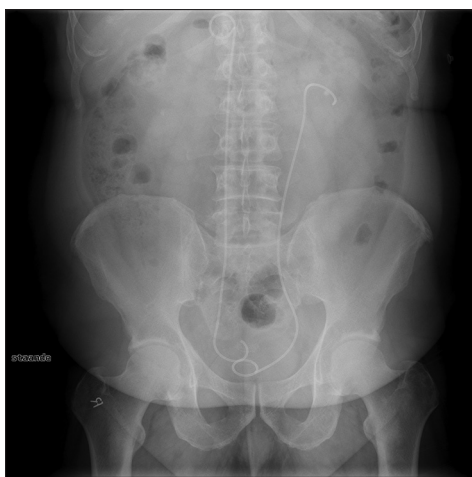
Peroperative kidneys, ureters, and bladder X-ray after the placement of double J stents bilaterally in a man with bilateral renal colic pain due to ureterolithiasis. The left stent was positioned correctly. The right stent projected cranially at T12 and showed a somewhat medial position, but a nice proximal curl was noted. Because of the suspicion of an aberrant position, a computed tomography scan was planned
